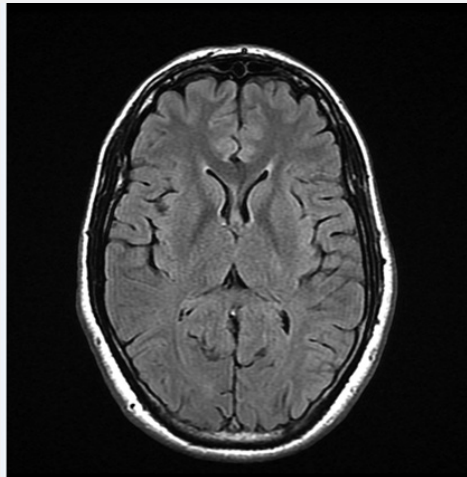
Brain MRI axial FLAIR (fluid attenuated inversion recovery) shows no abnormal signal intensity within the brain parenchyma.
